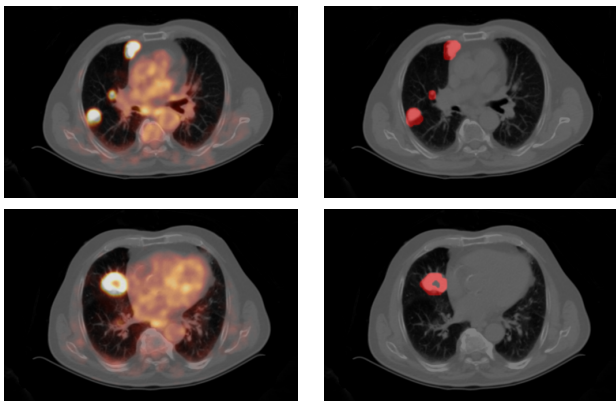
Left column: Axial slices of a positive case representing lung nodules on fused PET-CT views. Right column: Corresponding segmented lung nodules fused with the CT. Note the necrobiotic nodule on the bottom images, hence a hole is present in the middle of its mask.
